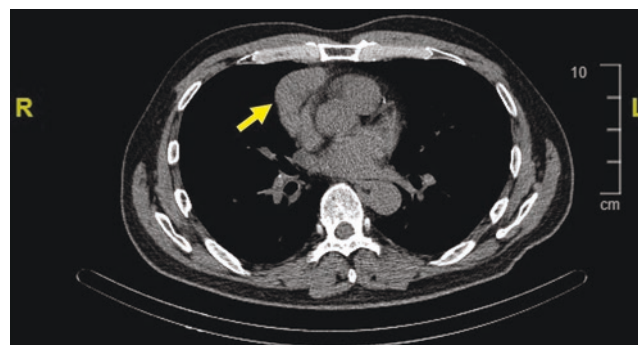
CT without contrast showing a solid anterior mediastinal mass with extension to the right lung (arrow)
